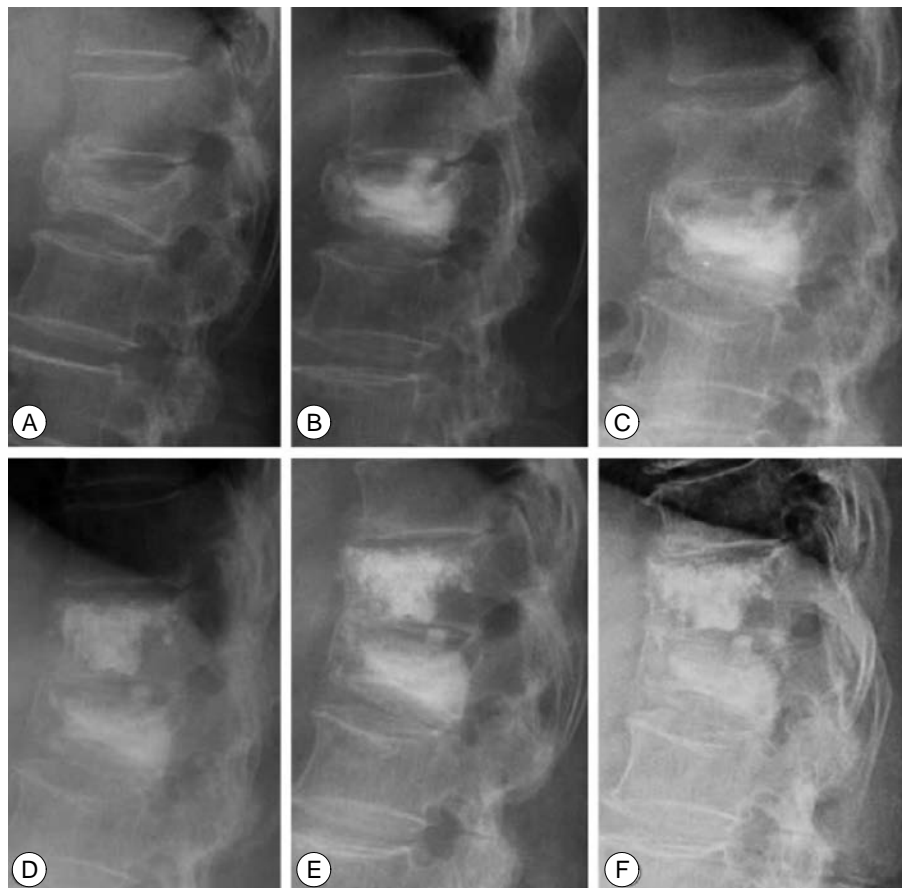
Simple lateral radiographs of a 73-year-old woman with L1,T12 compression fracture. (A) Preoperative radiograph showed L1 compression fracture, (B) Immediately postoperative radiograph of L1, (C) Postoperative 3 years follow-up radiograph show a new compression fracture on T12, (D) Immediately postoperative radiograph of T12 (3 years after L1 postoperatively), (E) Two years after vertebroplasty on T12, follow-up radiograph show a progressive bony bridging between T12 and L1, (F) Four years after vertebroplasty on T12, follow-up radiograph show a spontaneous fusion between T12 and L1.
